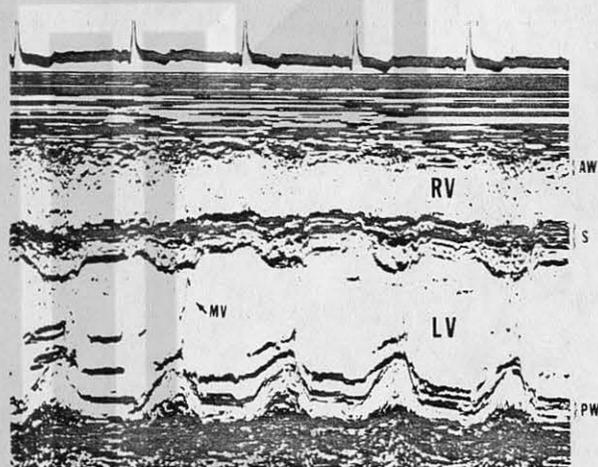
M-Mode Echocardiogram through the Body of the Right (RV) and Left (LV) Ventricles in a Normal Subject.
